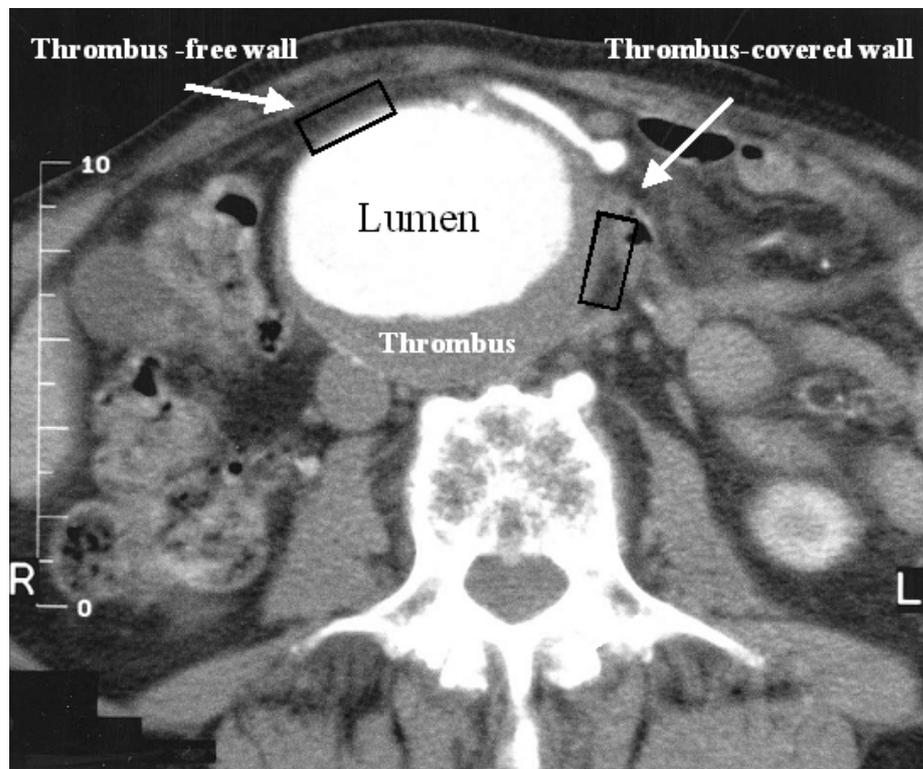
A CT scan representing the areas of sample collection of thrombus-covered and thrombus-free wall of AAA.
